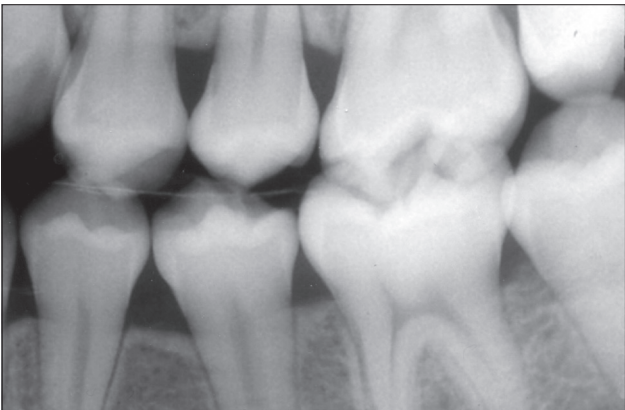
Final bite-wing radiograph of case No. 7 (2002). No evidence of periodontal disease in the permanent dentition is evident.
